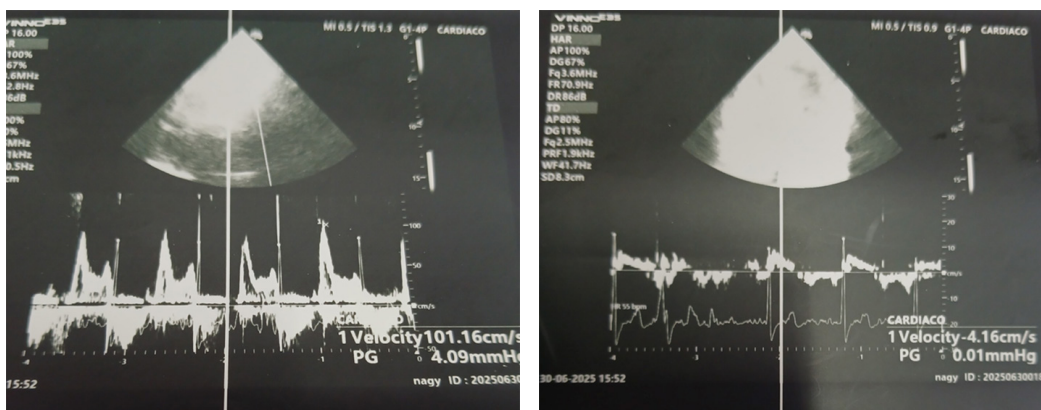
A. Severe diastolic dysfunction (grade 3). Altered ventricular compliance. The mitral flow pattern shows peak “E” velocity of 101 cm/s and peak A velocity of 33 cm/s, with an E/A ratio of 3.06. This pattern is observed in advanced or decompensated heart diseases. B. Severe diastolic dysfunction (grade 3). Mitral annulus tissue Doppler. e’ velocity is 4.16 cm/s and the E/e’ ratio is 24 , indicating high pulmonary capillary pressure. This pattern is observed in frequently symptomatic patients.
